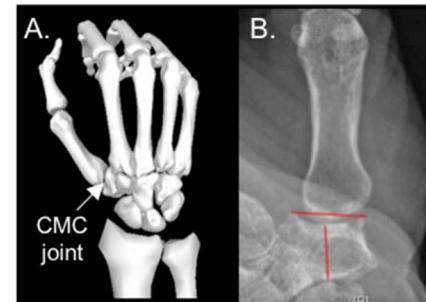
(A) The CMC joint connects the first metacarpal and trapezium. (B) X-ray of mild CMC OA from Ladd et al.¹
